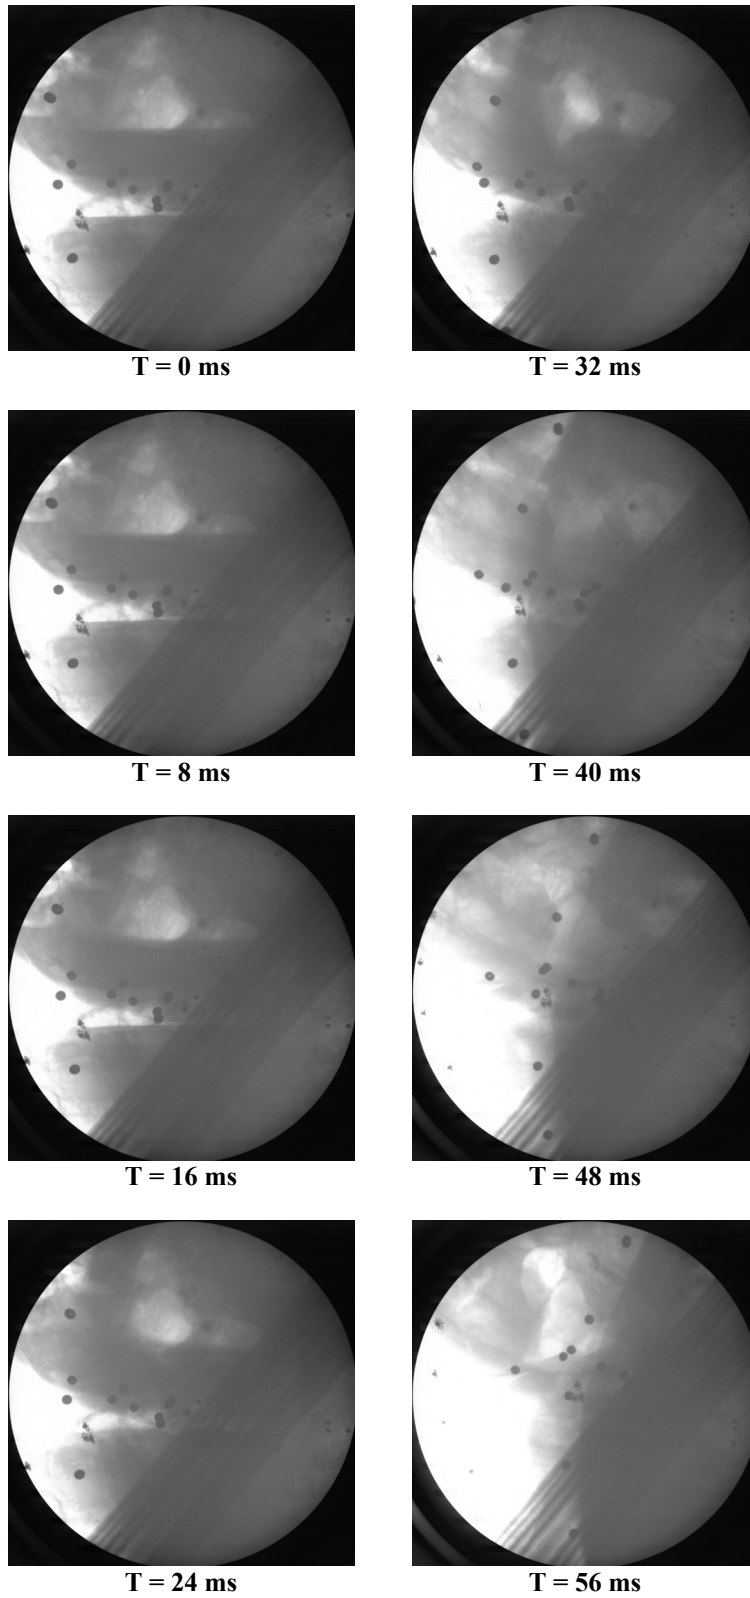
Seatbelt loading x-ray image sequence. §
